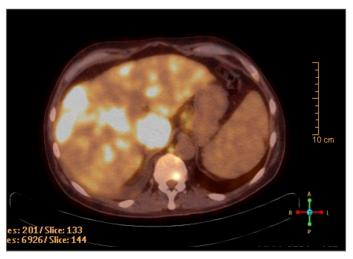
PET-CT. Hepatic involvement of lymphoma.
